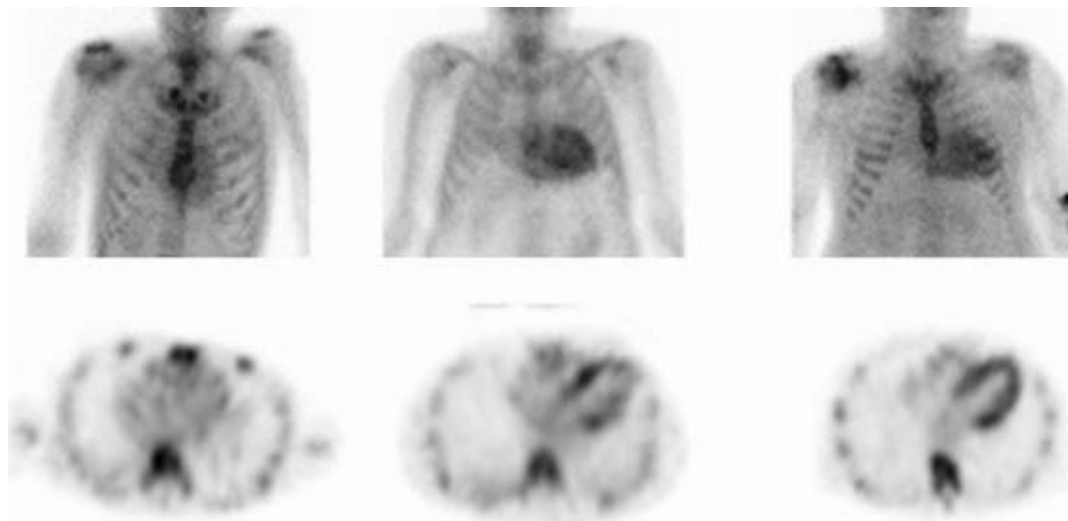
Sections of whole-body planar (top row) and chest SPECT (bottom row) ^{99m}Tc -pyrophosphate images. *Left panels*, Grade 0 uptake (no myocardial uptake), effectively excluding transthyretin cardiac amyloidosis. *Middle panels*, Grade 2 uptake (myocardial uptake equal to bone uptake). *Right panels*, Grade 3 uptake (myocardial uptake greater than bone uptake). Uptake of this tracer marks the myocardial deposition of TTR amyloid. (Images courtesy Sharmila Dorbala, MD.)
